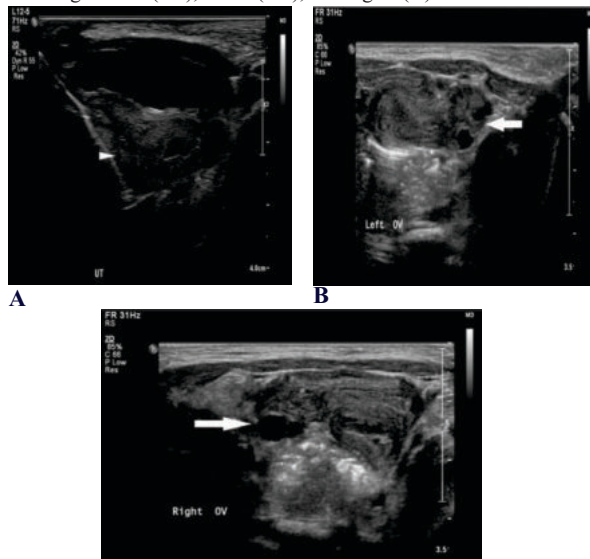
(A, B & C) Ultrasound pelvis demonstrates presence of the uterus (arrowhead) and both ovaries (arrows).
